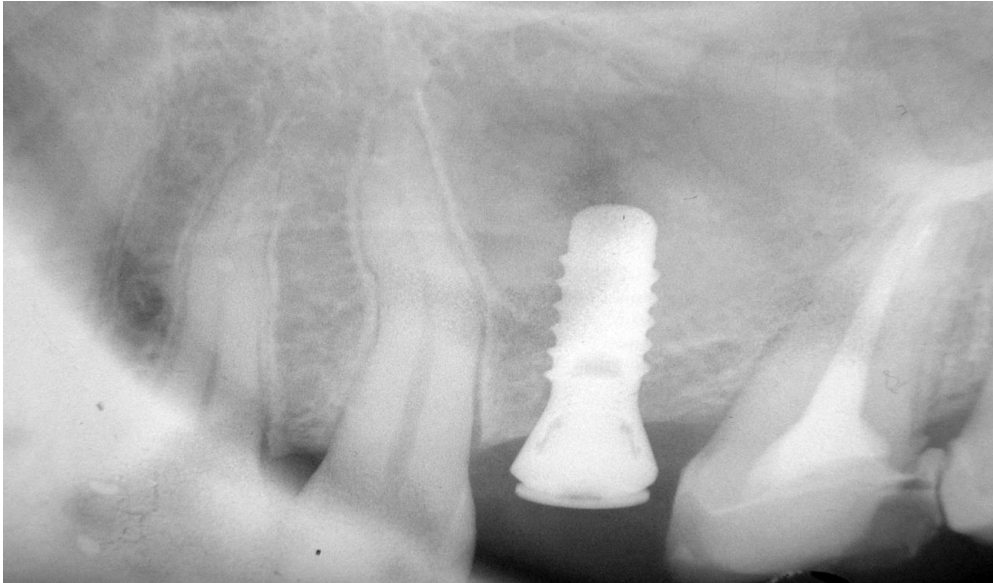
X-ray immediately after surgery.*
